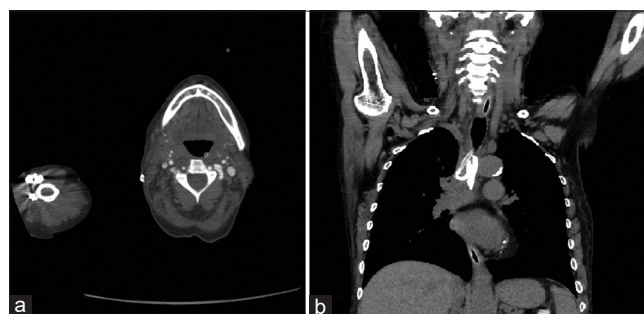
Neck and chest computed tomography after thoracotomy on the 6th day; (a) Axial projection of head-and-neck with volume reduction of the right laterocervical abscess (b) coronal projection of the chest with mediastinal drainage and the volumetric reduction of the mediastinal abscess
